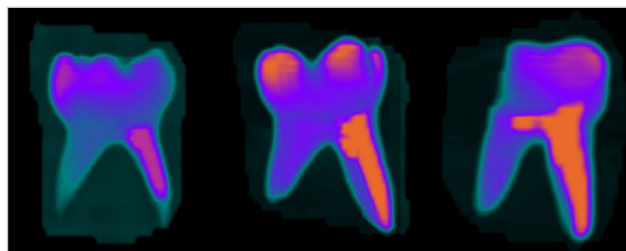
Spiral computed tomography slice showing 3 primary molar root canals obturated with zinc oxide eugenol, Metapex, and Vitapex, respectively (from left to right).
